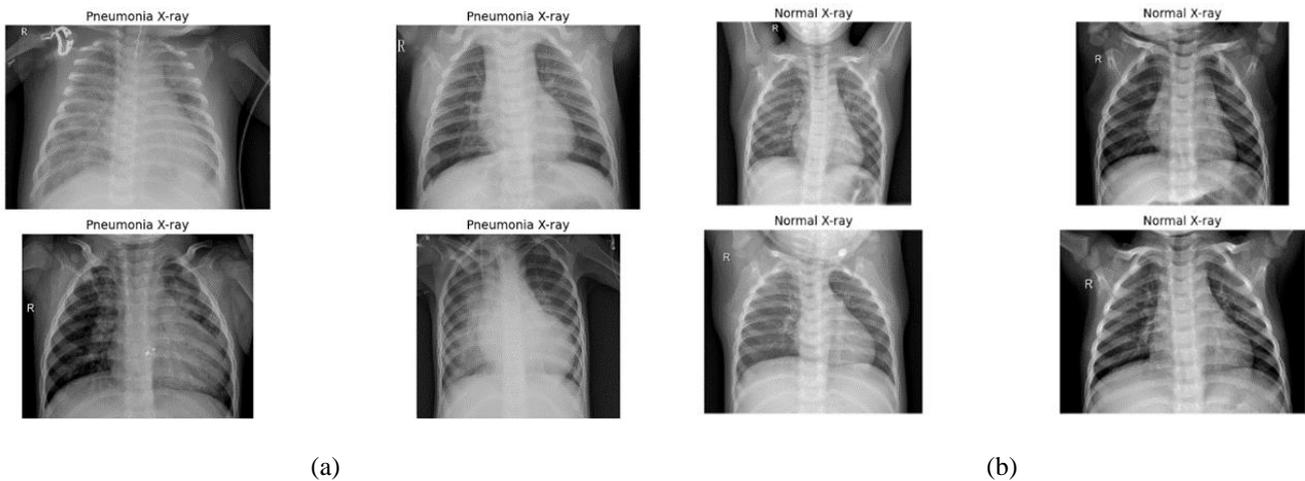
(a) Pneumonia X-rays dataset (b) Normal X-rays dataset
